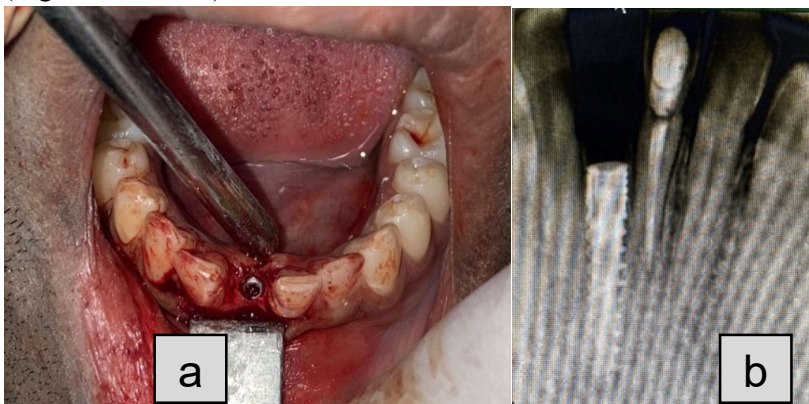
(a and b). Clinical and radiographic images showing the placed implant. After 15 days, the patient was recalled for follow-up. The implant had successfully osseointegrated after 3 months. During the final torquing of the abutment screw on the day of prosthesis cementation, the screw fractured at the apical third of the abutment channel (Figure 4) but attempts to retrieve it using an ultrasonic scaler tip failed.
